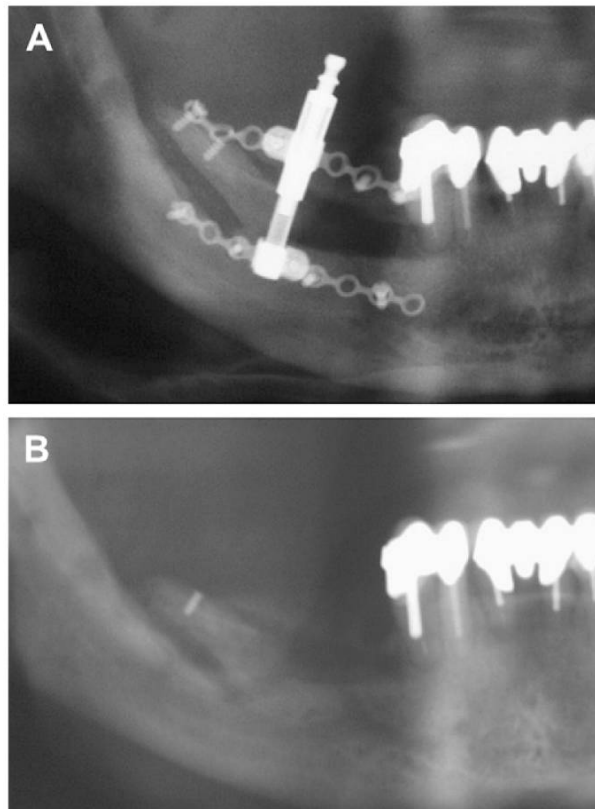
(A, B) Panoramic radiographs showing large fracture of transport segment that required the suspension of the procedure.
